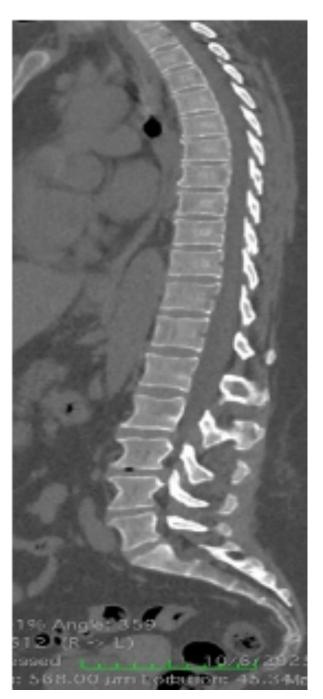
CT sagittal total spine reconstruction.
